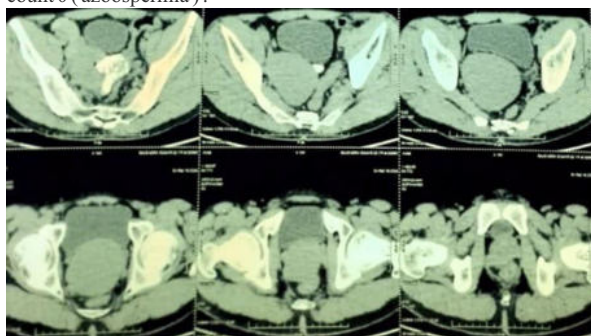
Axial view of CT urography showing 12.4 *7.6 cm cyst posterior to urinary bladder ? rt seminal vesicle cyst .
